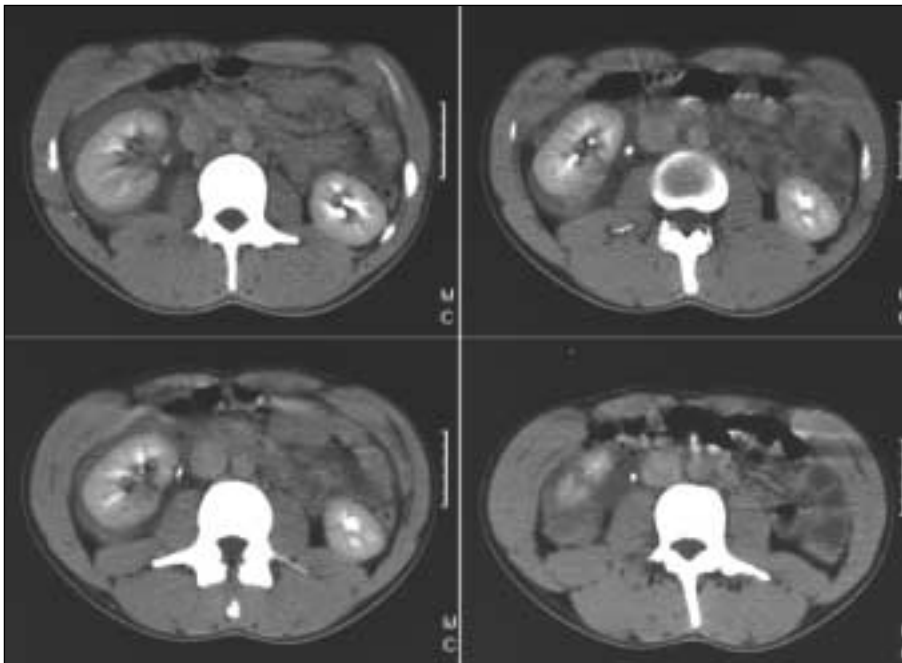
Postintravenous contrast enhanced CT scans.
